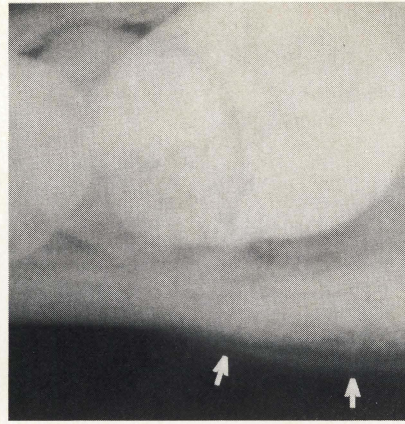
Cropped occlusal radiograph. Laminated "onion skin" bone formation (arrows) is evident on the buccal surface of the mandible.
